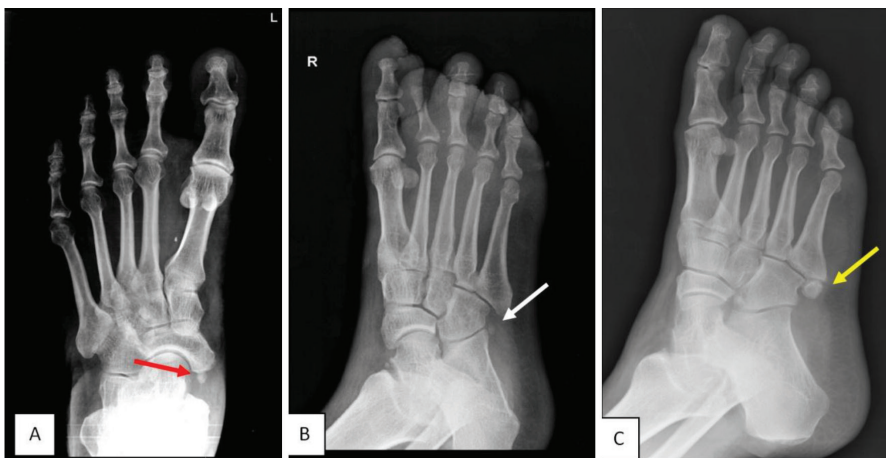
(A) AP view in foot radiograph showing Accessory navicular bone (red arrow), (B) and (C) Oblique view in foot showing Os Peroneum (white arrow) and Os vesalianum (yellow arrow). Technique- 50-55 kVp and 3 mAs in a 500 mA Allengers MARS 50+ x-ray machine
